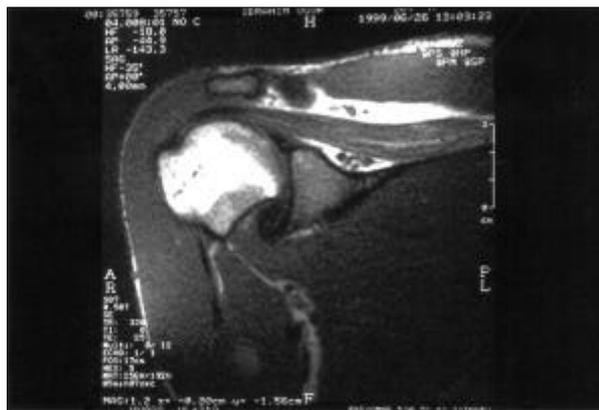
Magnetic resonance imaging shows right supraspinatus muscle atrophy.
